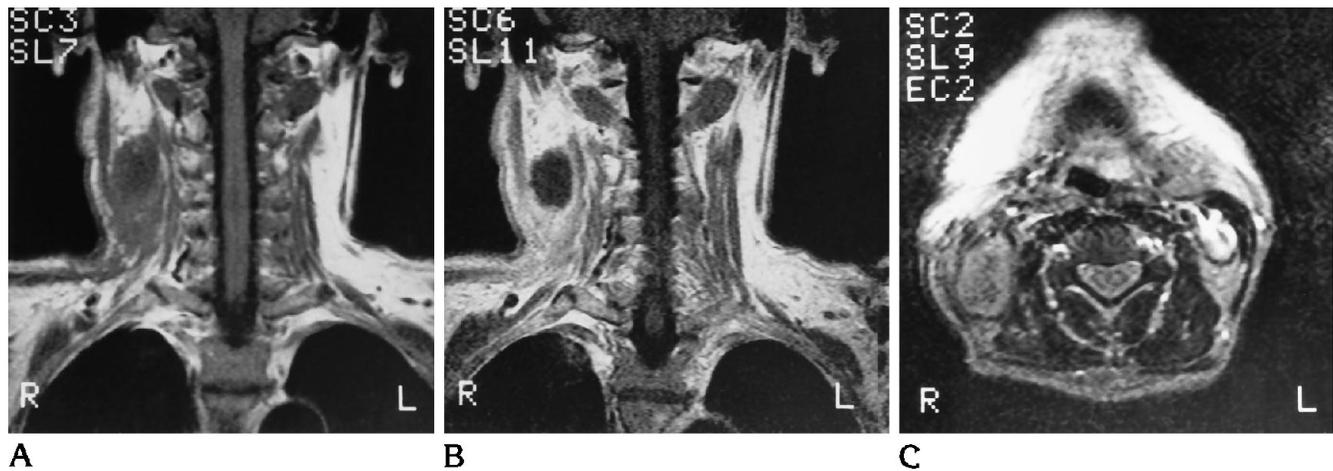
T1-weighted (450/20) coronal images before (A) and after (B) contrast administration demonstrate a hypointense mass with peripheral contrast enhancement.
